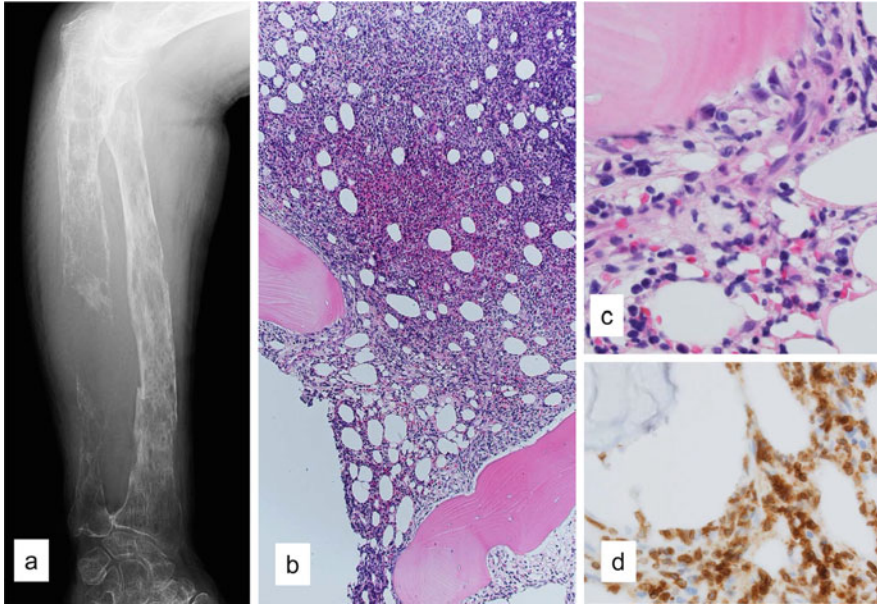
Bone and bone marrow of ATL. (a) A radiograph of the leg shows extensive lytic bone lesions. (b) The bone marrow shows diffuse infiltration of lymphoma cells. (c) The lymphoma cells are pleomorphic medium-sized and large-cell type. And osteoclasts of the peri-trabeculae are increased in number. (d) The lymphoma cells react with CD3 antibody
